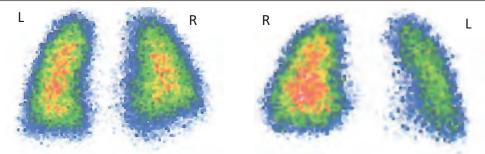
Patient U.M. Pulmonary perfusion scintigraphy in two incidences (anterior and posterior) performed 6 months after discharge. The uneven distribution of the radiopharmaceutical was detected bilaterally, with the preservation of the blood flow within the limits of normal values in the right lung, in the left lung being observed the diffuse decrease of the pulmonary blood flow more evident in the anterior segments
